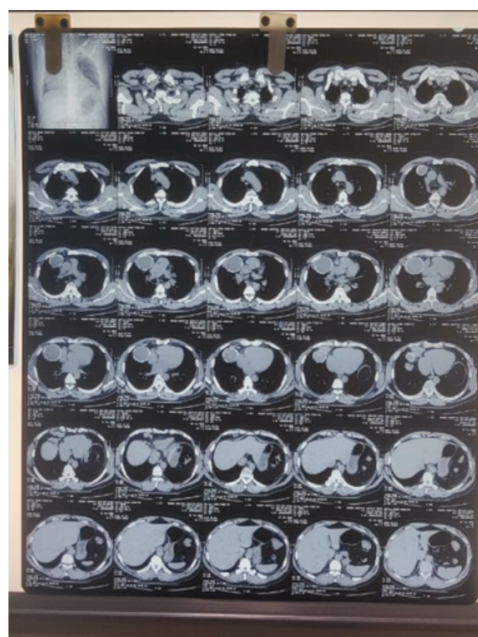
Pre-procedural Computed Tomography (CT) of the chest.
